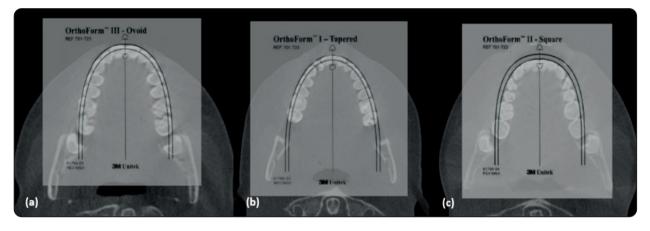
Classification of (a) the maxillary dental arch as ovoid, (b) the maxillary dental arch as tapered, and (c) the mandibular dental arch as square, by superimposition of the premanufactured arch form templates (OrthoForm, 3M, Unitek) onto the axial CBCT images of the dental arch using Picsart Photo Editor.
